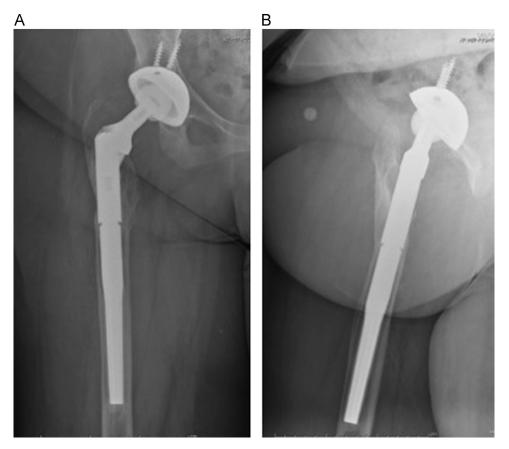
Figure – (A and B) The 13-year follow-up anteroposterior and lateral radiographs of a hip that was re-implanted following periprosthetic infection in a 50-year-old woman. Evidence of osteointegration and remodeling following an extended trochanteric osteotomy are evident.
